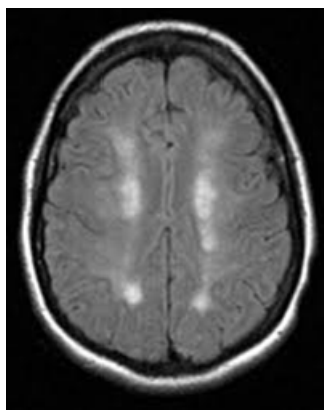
MRI brain, T1, transversal
